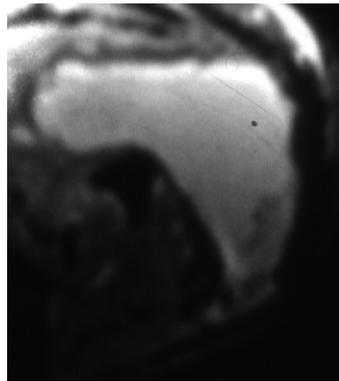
Cross sectional MRI scan of the patient's left calf revealing a large fluid collection (arrow).
